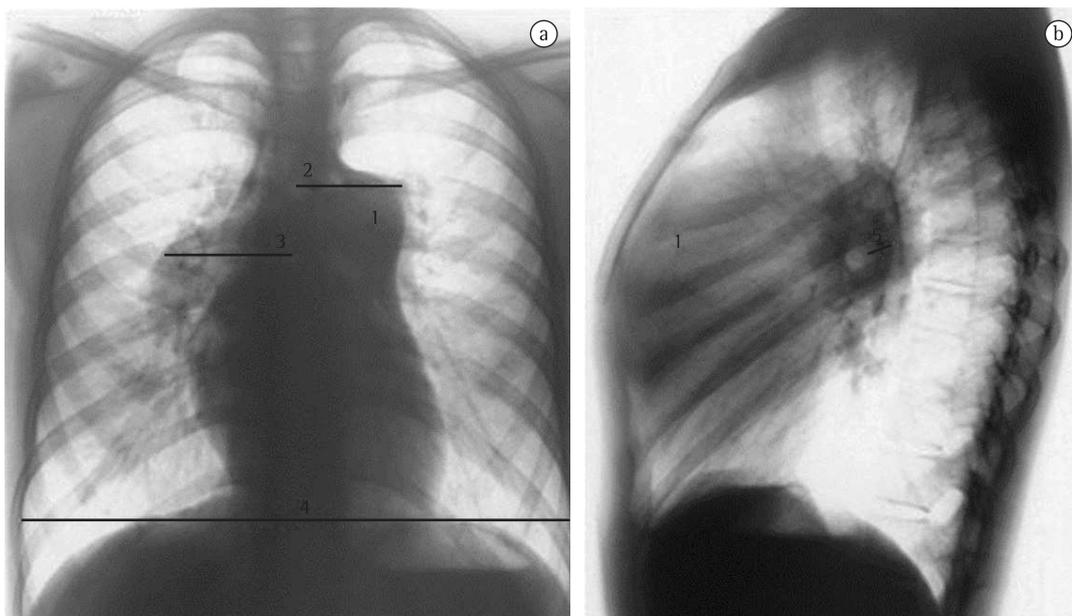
Posteroanterior chest X-ray (in a) and lateral chest X-ray (in b) of a 28-year-old female patient with idiopathic pulmonary arterial hypertension. Note the dilated pulmonary artery trunk (1), the hilar-thoracic index (2) + (3) > 38% (4), and the left pulmonary artery > 18 mm (5) in profile.
